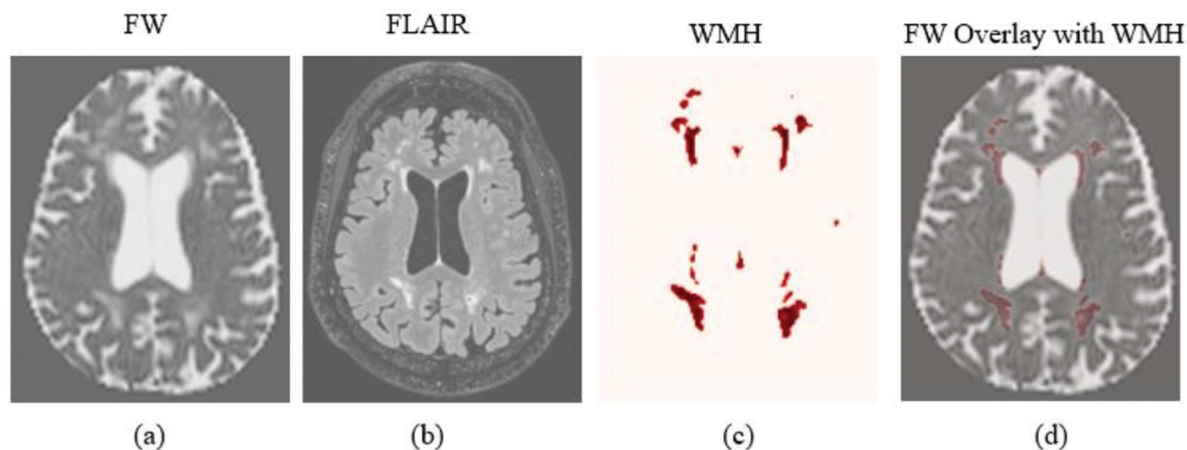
Representative images from an individual subject. (a) Free water (FW) map, (b) T2-weighted FLAIR image, (c) White matter hyperintensity (WMH) segmentation from the FLAIR image, and (d) Overlay of WMH on the FW map.
